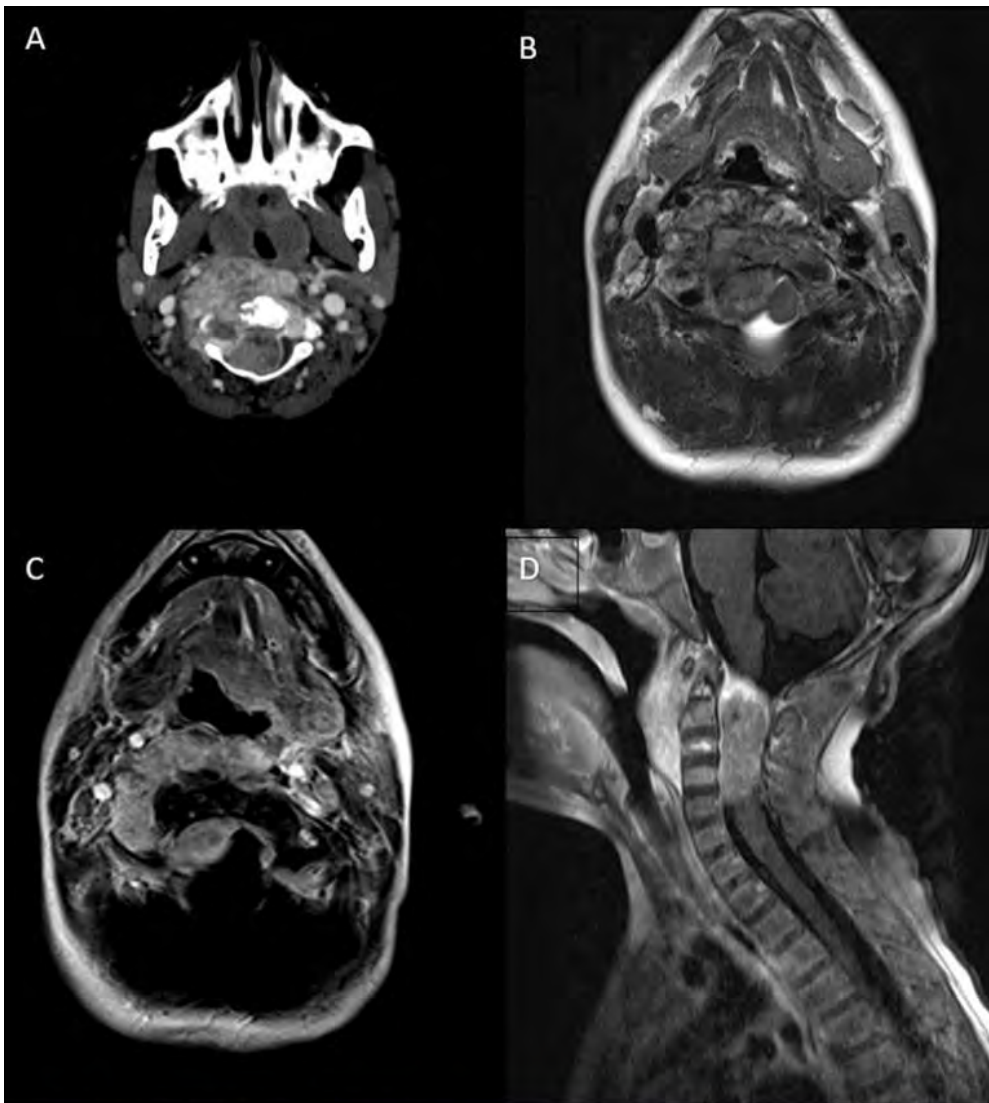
(A) CT Neck with IV Contrast – Axial view (B) Cervical MRI Axial T2 (C) Cervical MRI T1 Axial Post Contrast (D) Cervical MRI Sagittal T1 Post Contrast
